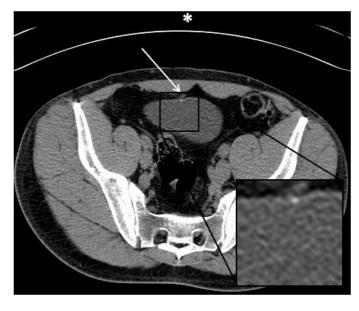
(left): 42 year old man with renal colic revealing a calcified urachal remnant. Axial unenhanced CT of the abdomen and pelvis (window level 35 HU, window width 350 HU) with the patient in the prone position (* indicates the CT table top) performed 3 years earlier. The image reveals the same small calcific density (white arrow) in the anterior aspect of the urinary bladder, unchanged on subsequent imaging 3 years later confirming the diagnosis of calcified urachal remnant. The area of interest is magnified is the lower right corner (Protocol: 120 kV, 95 mAs, 3 mm slice thickness).
